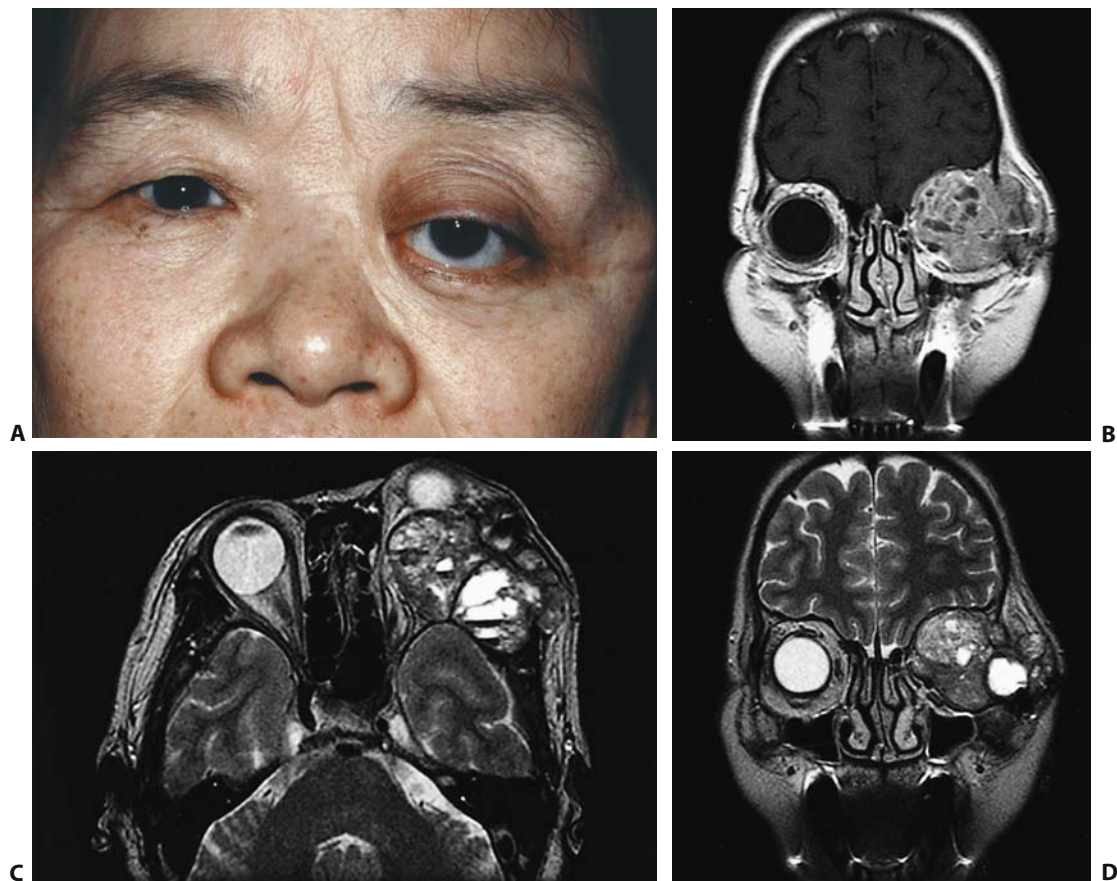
Pleomorphic adenoma. (A) A 68-year-old woman had had long-standing proptosis and downward displacement of the left eye for 30 years. She had experienced two recurrences after incomplete removal 15 years ago. (B) T1-weighted coronal MR image shows the huge mass of heterogeneous intensity filling the entire
